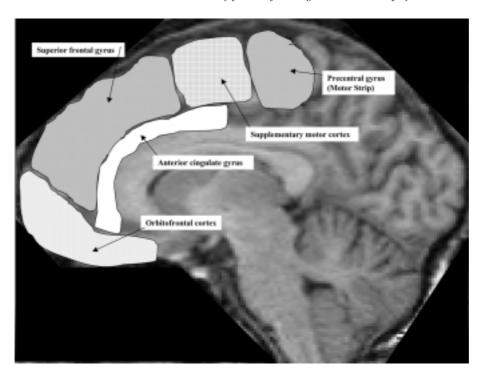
Medial view of anatomic locations of selected frontal lobe subdivisions as displayed on a midsagittal T1-weighted MRI scan.
